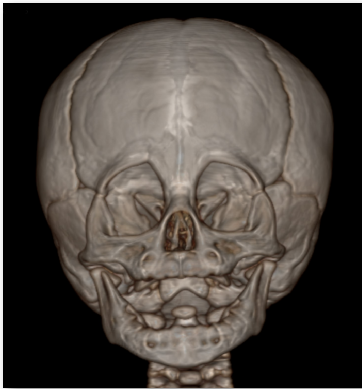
3D-CT scan of child with metopic synostosis
